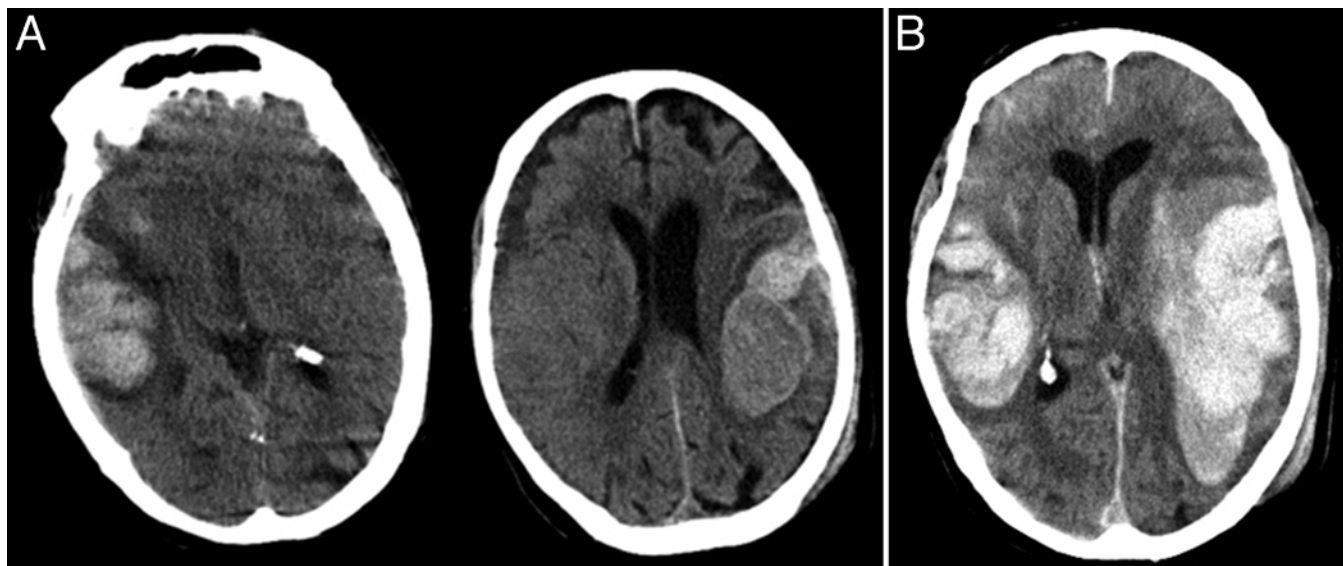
Noncontrast head CT scans. A: Study obtained approximately 2.5 hours postadmission showing significant interval evolution of the patient's intracranial hemorrhage bilaterally. B: Study obtained 6 hours postadmission revealing significant further progression of the patient's intracranial hemorrhage.
